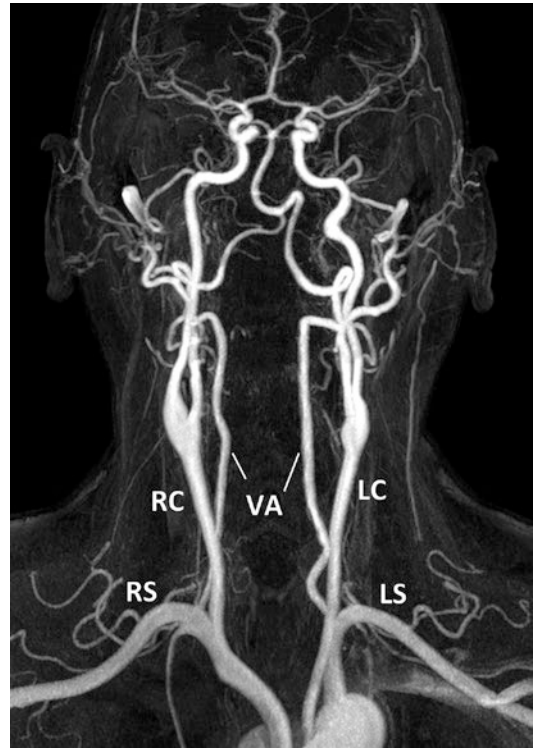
Normal aortic arch, MRI angiography. Brachiocephalic trunk (BR), from which arise the right common carotid (RC) and the right subclavian (RS) arteries. Common left carotid (LC), left subclavian artery (LS). Normal origin of both vertebral arteries (VA). That of the right is smaller. The VAs join intracranially the BA. The bifurcation of the two common carotid arteries is well demonstrated as well as the intracranial ICA branches
